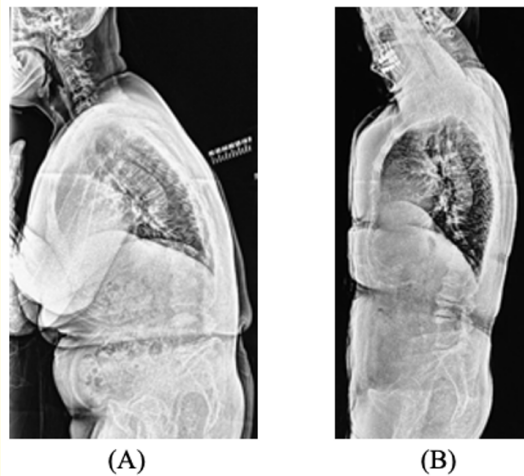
Lateral plain radiographs of the spine. (A) A lateral standing plain radiograph shows kyphotic deformity of the thoracic spine and a sagittal vertical axis of 185 mm at C7. The age-related kyphosis in this patient was flexible, with a decrease in the thoracic kyphosis angle to about 10 degrees in the lying position (B) from about 50 degrees in the standing position (A).
